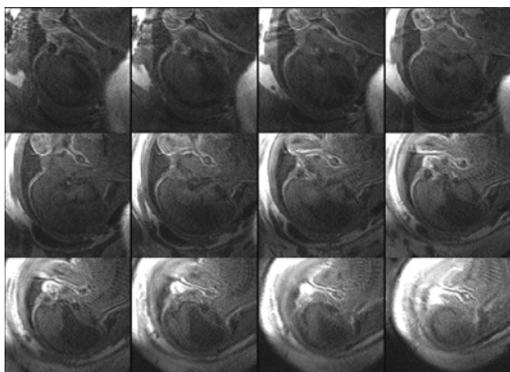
In utero MRI of the brain of fetus suffering from a pronounced case of ventriculomegaly. Twelve out of sixteen FGRE slices are shown that were acquired within a breathhold of 15sec. Morphologic details of the fetal brain and the enlarged ventricles can be clearly delineated.
